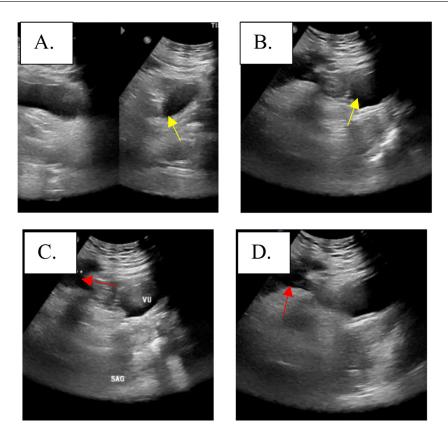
Abdominal USG (A and B) The urinary bladder of this patient is visible through abdominal USG (yellow arrow). (C and D) Abdominal ultrasound with urachal cyst (a heterogeneous, hypoechoic, well-defined, regular-edged, semi-solid mass without calcification measuring  $7.35 \times 6.21 \times 9.24$  cm in the lower abdomen.) (red arrow).
